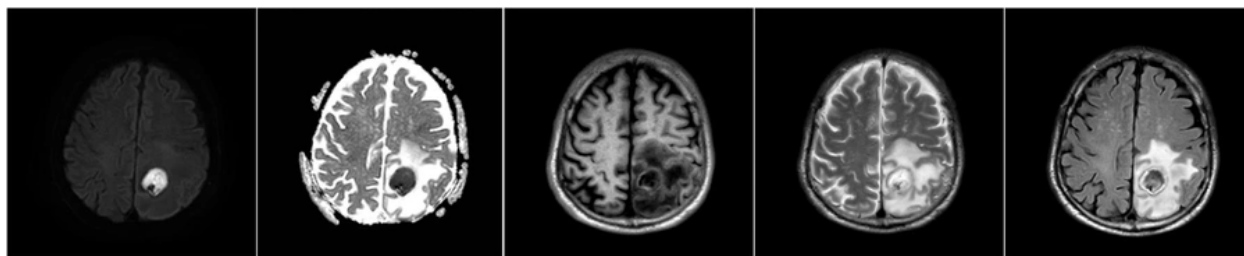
Brain magnetic resonance imaging (MRI) demonstrates a well-circumscribed round lesion measuring approximately 2.3×2.7 cm in the left parietal lobe. A, The lesion shows an isointense capsule on both T1- and T2-weighted images, with hypointense signal on T1-weighted imaging and hyperintense signal on T2-weighted imaging within the cystic cavity. B, Prominent perilesional vasogenic edema with mild mass effect is observed. C, Diffusion-weighted imaging reveals marked hyperintensity with restricted diffusion, consistent with a cerebral abscess.
